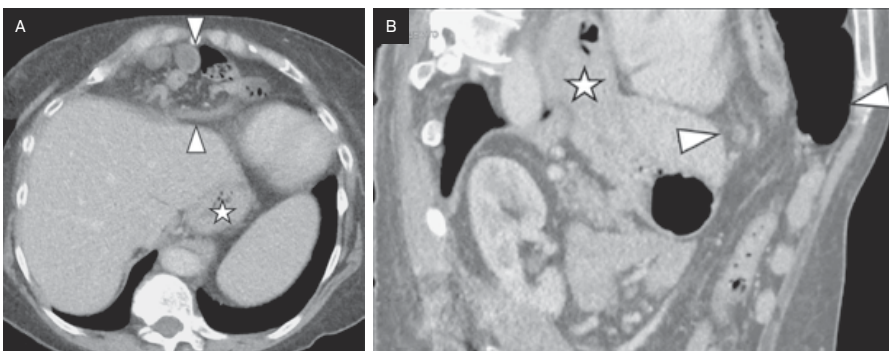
Axial (A) and mid-sagittal (B) abdominopelvic CT sections obtained 10 years after Figure 1 showing the significant interval increase in size of the Morgagni hernia (outlined by arrowheads), located in the right anterior mediastinum, through the expanding sub-costosternal diaphragmatic defect. Note is made of a coexisting paraesophageal hernia (star), with approximately 40% of the stomach within the thoracic cavity.
